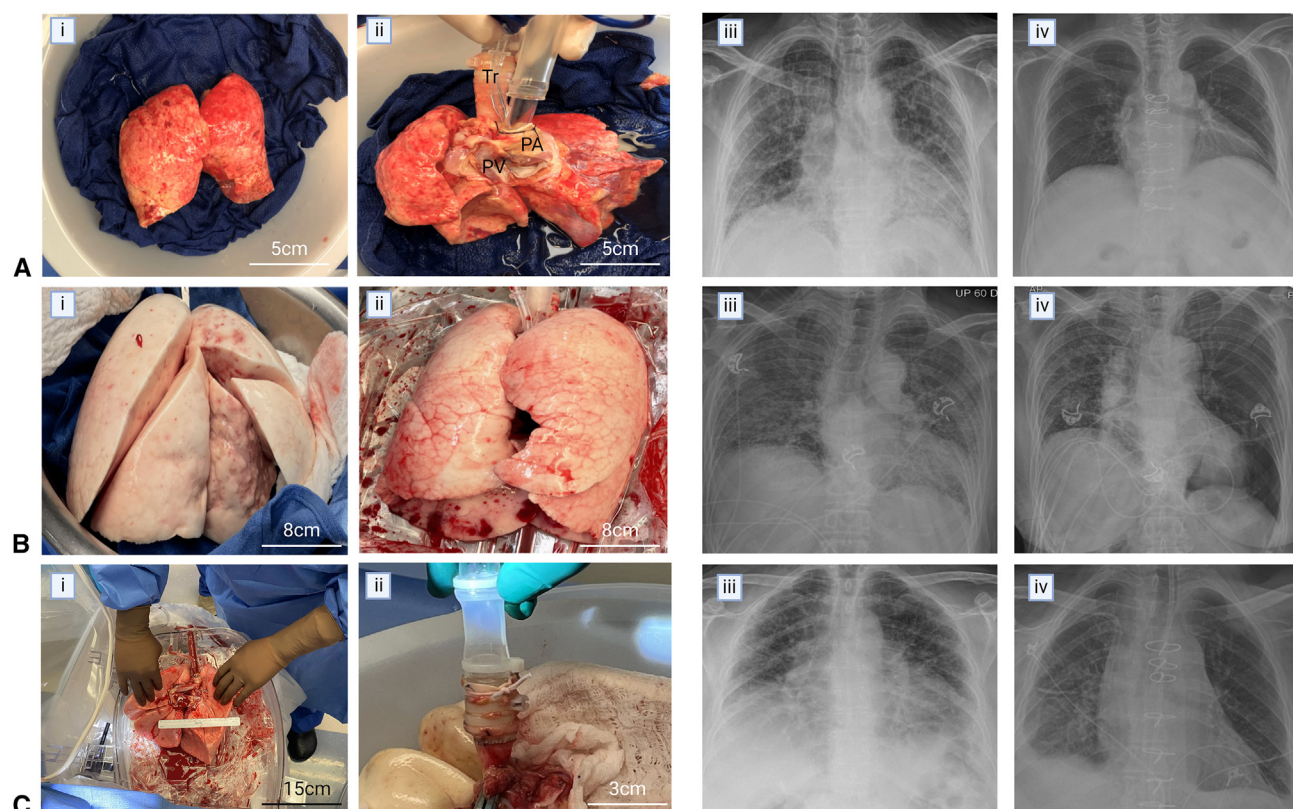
A, Pediatric lungs precannulation (i) and postcannulation (ii) (left to right), and preoperative (iii) and discharge chest radiograph (iv) of the first patient. B, Pediatric lungs before (i) and after ex vivo lung perfusion (EVLP) (ii) and preoperative (iii) and discharge chest radiograph (iv) of the second patient. C, Donor 3's trachea was too narrow to fit the ventilation cannula adaptor (i), so a short segment of ascending aorta was anastomosed to the end of the trachea for the duration of EVLP (ii). The anastomosis was airtight, and ventilation parameters were met without issue. Preoperative (iii) and discharge (iv) chest radiograph of recipient 3. Tr, Trachea; PA, pulmonary artery; PV, pulmonary veins.
